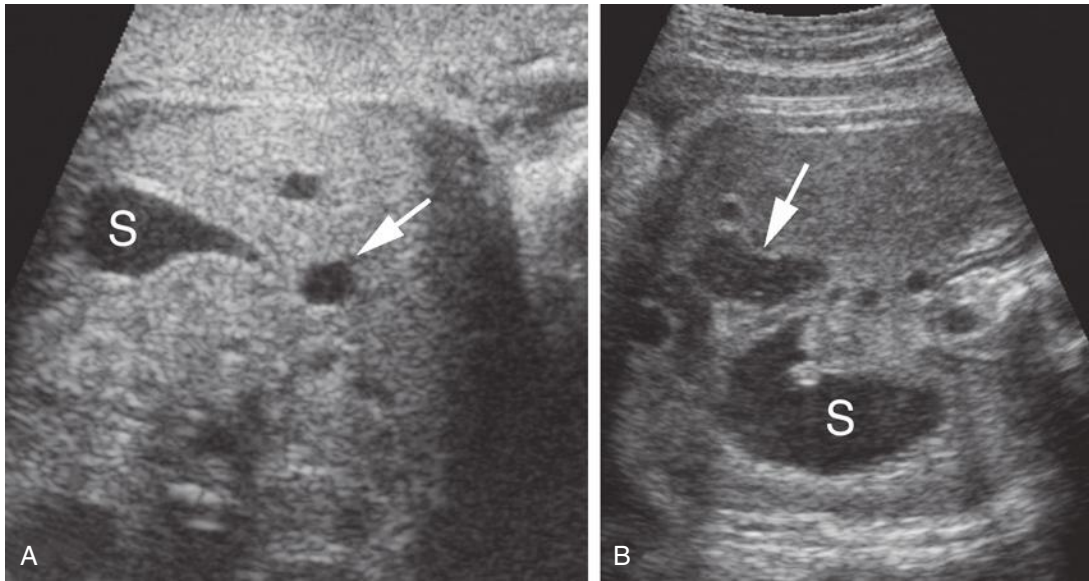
Pseudo-double bubble sign. The double bubble may be seen in cases of duodenal obstruction and has been associated with trisomy 21. A, In this case, the fluid-filled structure adjacent to the stomach (S) is the gallbladder (*arrow*) and not the duodenum. B, A sonogram of the fetal abdomen in the third trimester demonstrates a prominent segment of colon (*arrow*) adjacent to the fetal stomach (S) and should not be misinterpreted as dilated duodenum.
